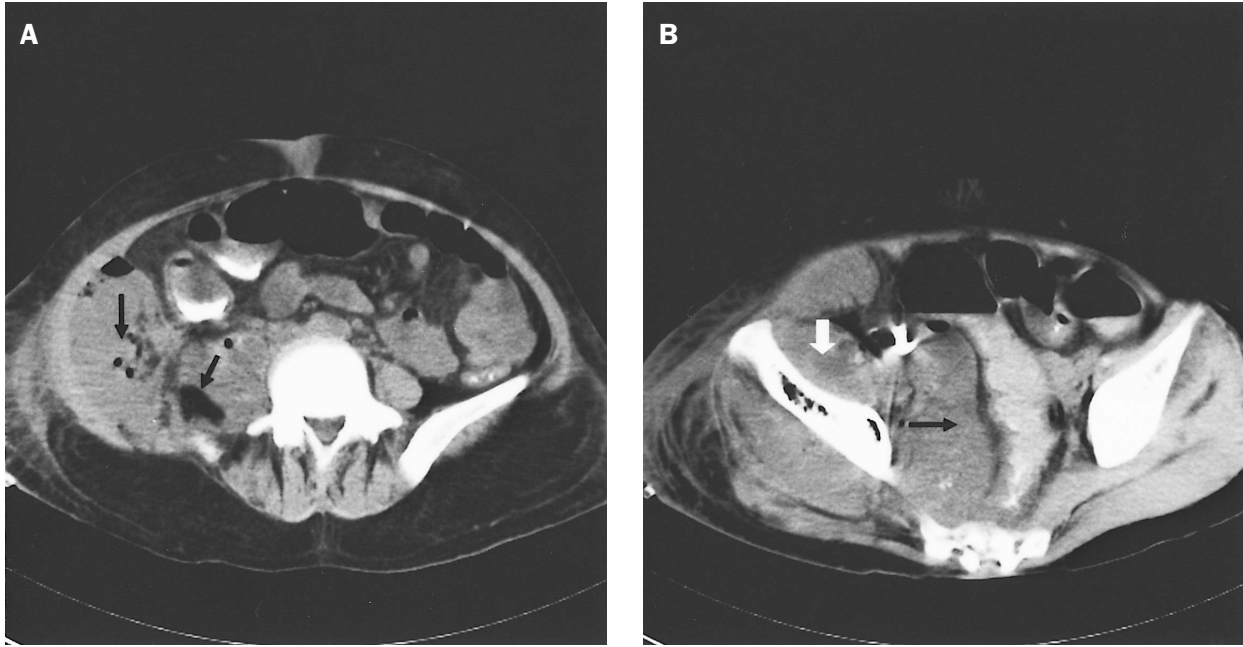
(A) An abdominal CT scan revealed a huge abscess (arrows) with gas formation over the right pararenal space with swelling of the psoas and iliac muscles. (B) A huge pelvic abscess with displacement of the intestine and sigmoid colon to the left side (black arrow) and swelling of the obturator muscle (white arrows).
